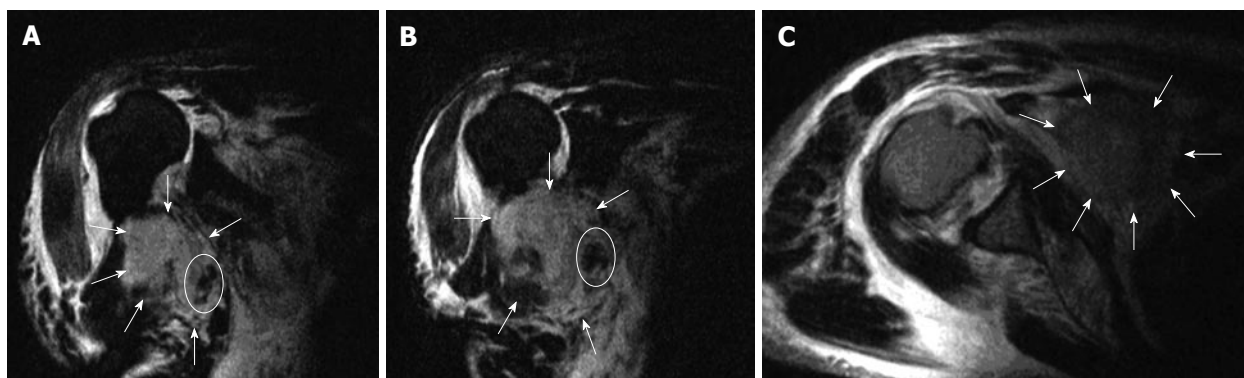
Open magnetic resonance imaging coronar STIR T2 (A and B) and axial TSE T2 (C) sequences representing a large retropectoral hematoma (arrows) compressing the neurovascular bundle (ellipse). Note striking raised position of the humeral head due to massive rotator cuff tears (A and B).
